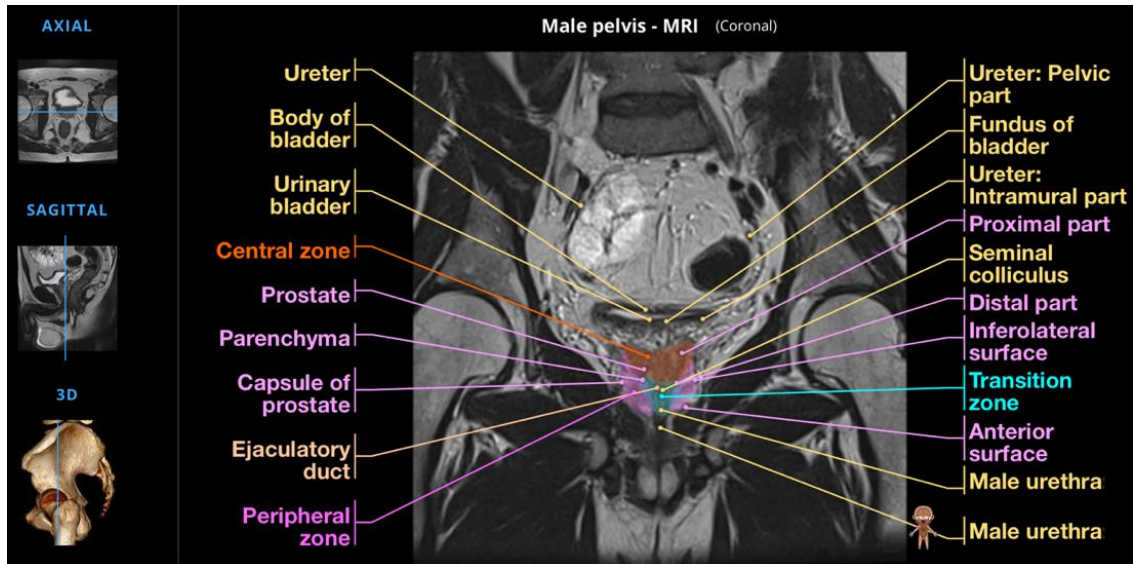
A T2-weighted MRI scan of a typical male pelvis provides visualization of the anatomy and zones of the prostate, urinary system including the bladder, ureter, and urethra. The scan also displays the ejaculatory duct. Obtained from (20).
